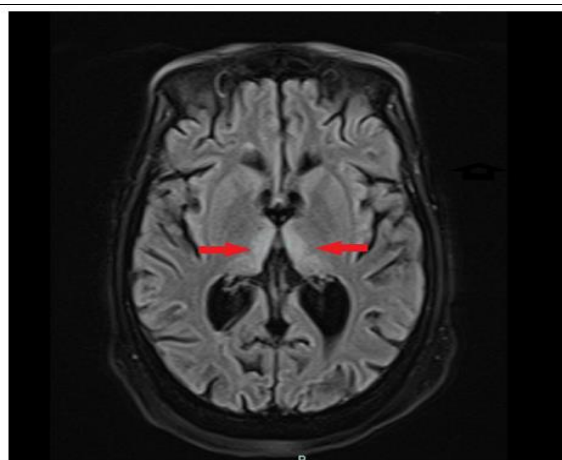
Magnetic resonance imaging (MRI) scan of the brain; red arrows show a symmetric hyperintense signal within the bilateral medial thalamic region.
